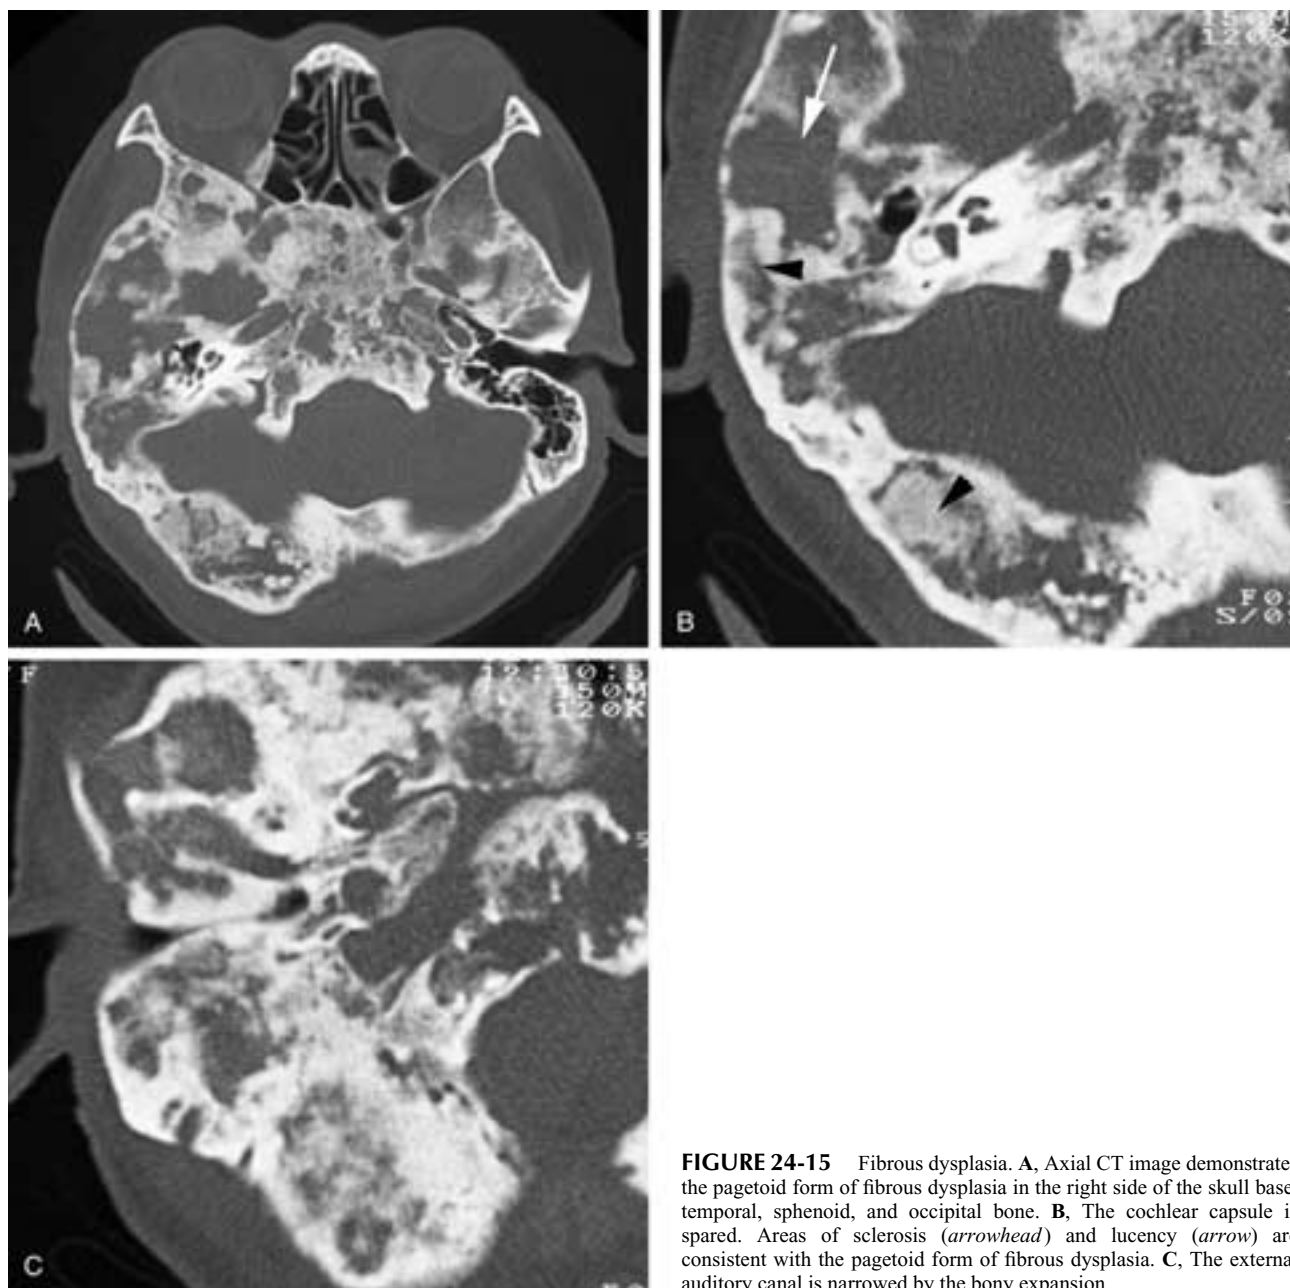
Fibrous dysplasia. A, Axial CT image demonstrates the pagetoid form of fibrous dysplasia in the right side of the skull base, temporal, sphenoid, and occipital bone. B, The cochlear capsule is spared. Areas of sclerosis (arrowhead) and lucency (arrow) are consistent with the pagetoid form of fibrous dysplasia. C, The external auditory canal is narrowed by the bony expansion.
